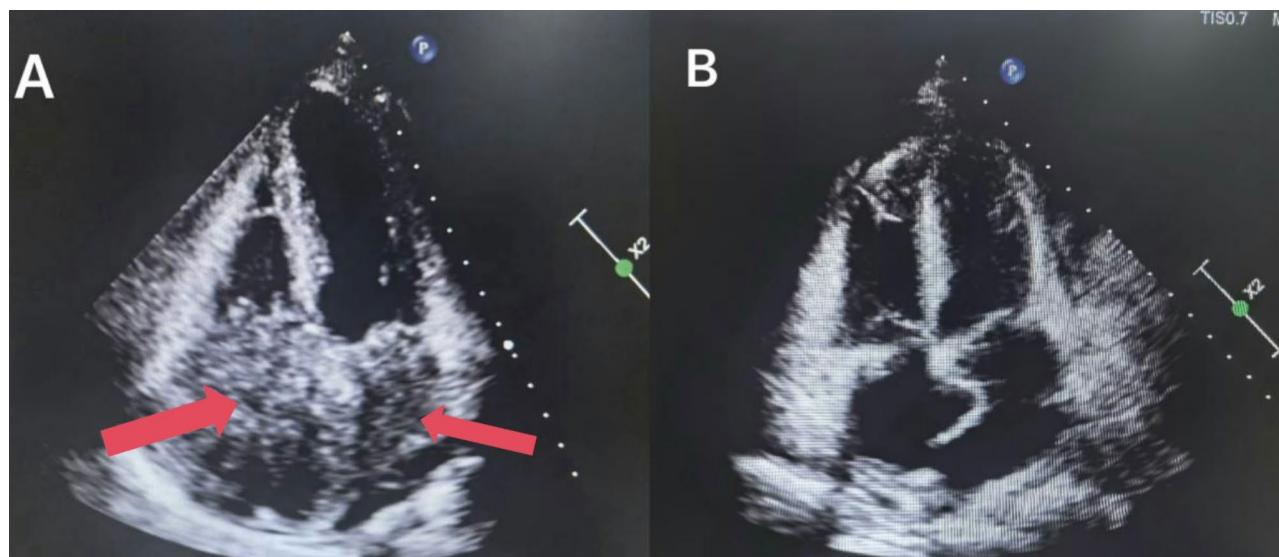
Transthoracic echocardiography, apical four chamber view showing: (A) preoperative huge atrial mass (arrow indicates cardiac mass), (B) postoperative
